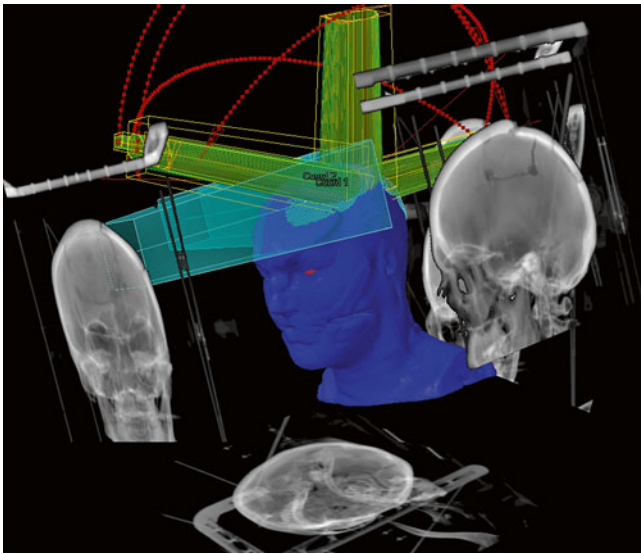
Image-guided radiation therapy (IGRT). Patient positioning is verified by X-ray images taken directly before treatment. Treatment images are matched to reconstructed images from the planning CT (shown in gray) by using sophisticated software to adjust the treatment table in 6 rotation axes. This guarantees a high precision in dose application. The *blue* figure represents a patient's head in a stereotactic RT mask. The *yellow and green* beams represent the stereotactic photon beams
